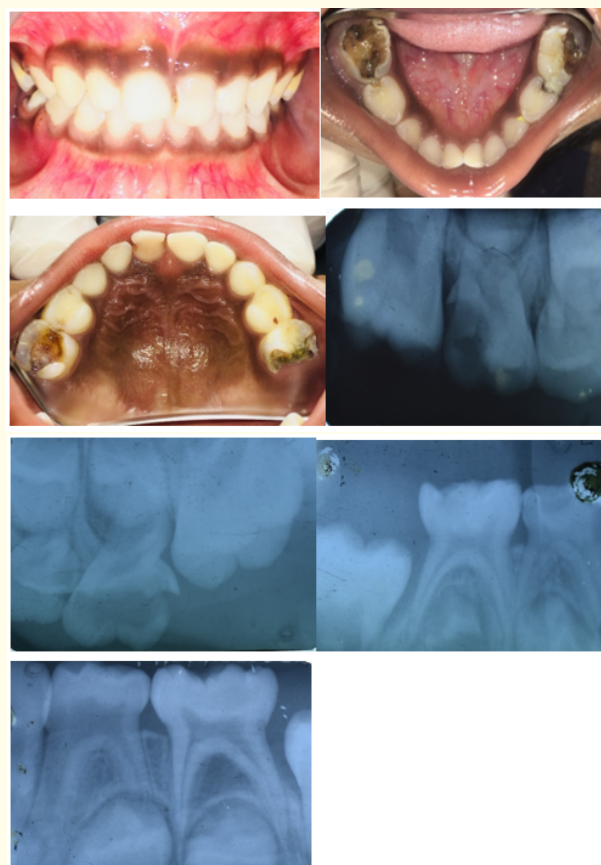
Intra-oral preoperative photograph and radiograph showing early childhood caries destruction.
